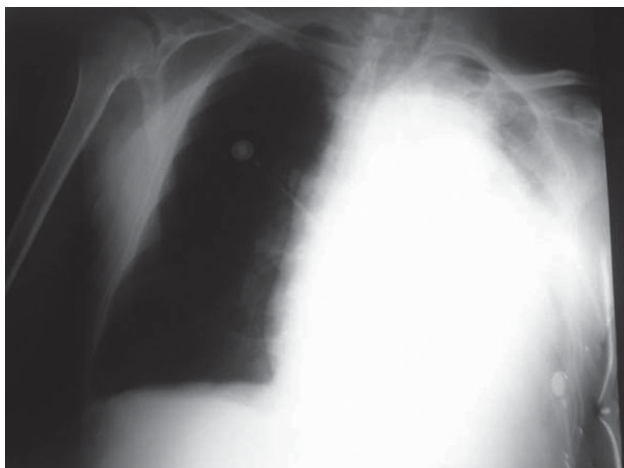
Chest radiography with partial opacification of the whole left hemithorax; disappearance of the cardiac silhouette and mediastinal structures; with deviation of the trachea to the left
